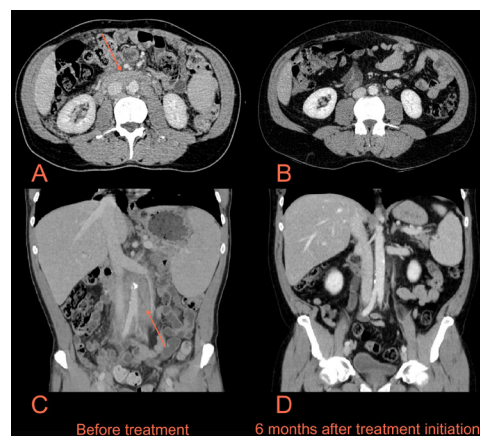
CT images of the abdomen before treatment (A, C) and six months after immunotherapy initiation (B, D). A lymphomatous mass surrounding the inferior vena cava and aorta could be seen (arrows on A and C). Follow-up CT showed resolution of the mass, with residual mild fat stranding surrounding the great vessels.
